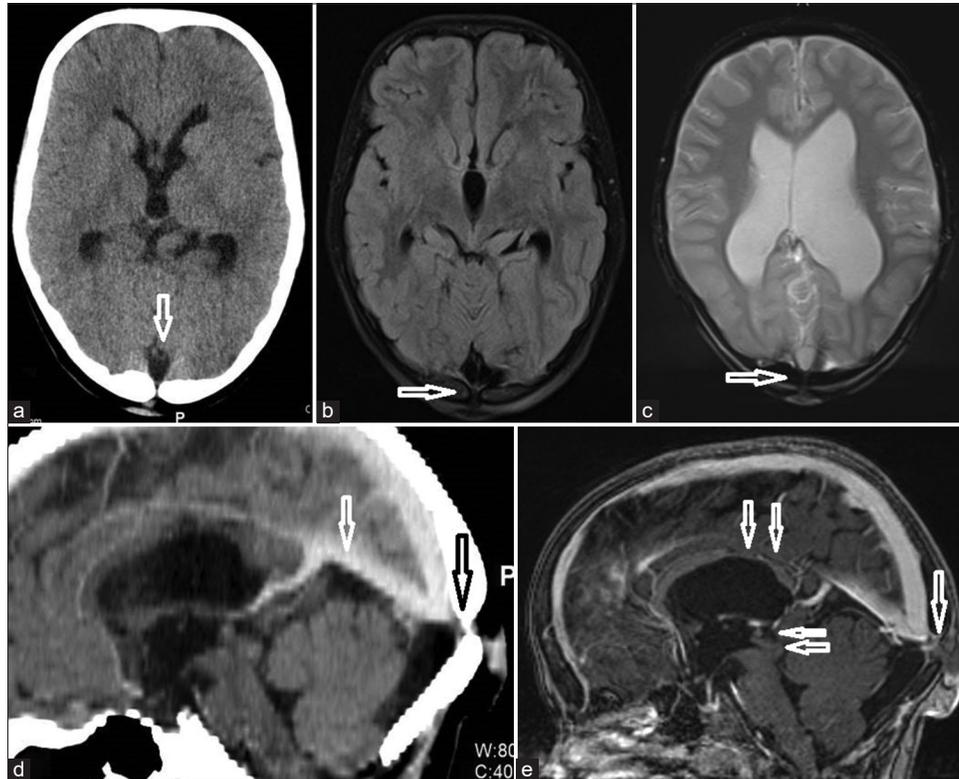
Case 1. Plain CT axial (a), MRI fluid attenuated inversion recovery axial (b), GRE T2* axial (c), Showing occipital bone defect at the level of Torcula. No herniation of CSF or neural tissue noted. Thin fibrous structure is seen extending from the meningeal margin into the defect. Contrast CT sagittal reformation (d), and contrast MRI T1-weighted images showing normal straight sinus along with hypoplasia of posterior corpus callosum and beaked tectal plate (vertical and horizontal double arrows in (e)). MRI: Magnetic resonance imaging, CT: Computed tomography, CSF: Cerebrospinal fluid.
